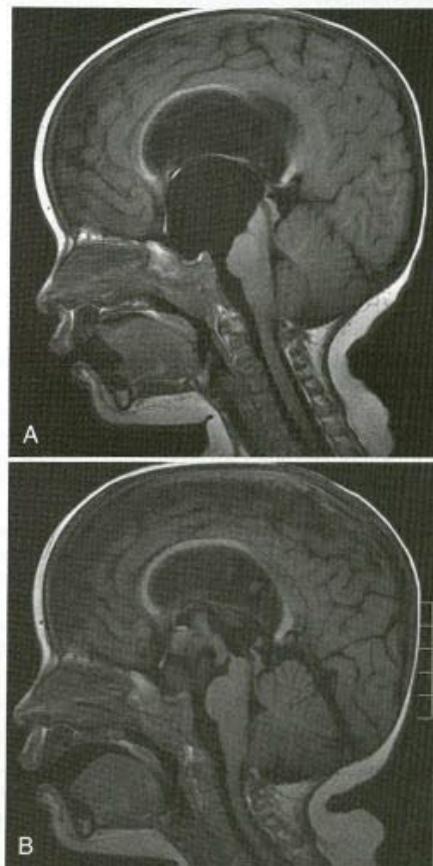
Magnetic resonance images of a 16-month-old girl with a progressively enlarging head from obstructive hydrocephalus secondary to suprasellar arachnoid cyst before (A) and 6 months after (B) endoscopic cyst fenestration into the third ventricle and preponine cistern.
